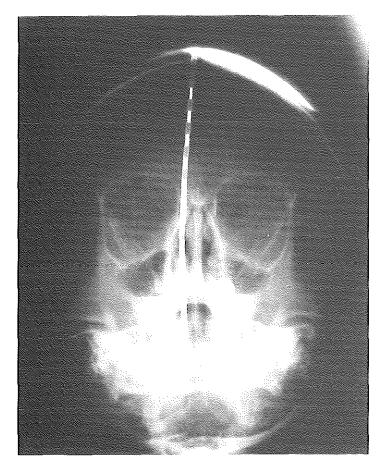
Antero-posterior skull X-ray with calibrated placebo applicator in situ (f, 4.75 yr).
